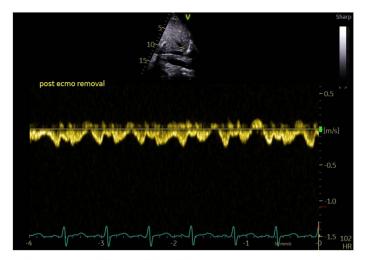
Post de-cannulation, hepatic vein Doppler.
